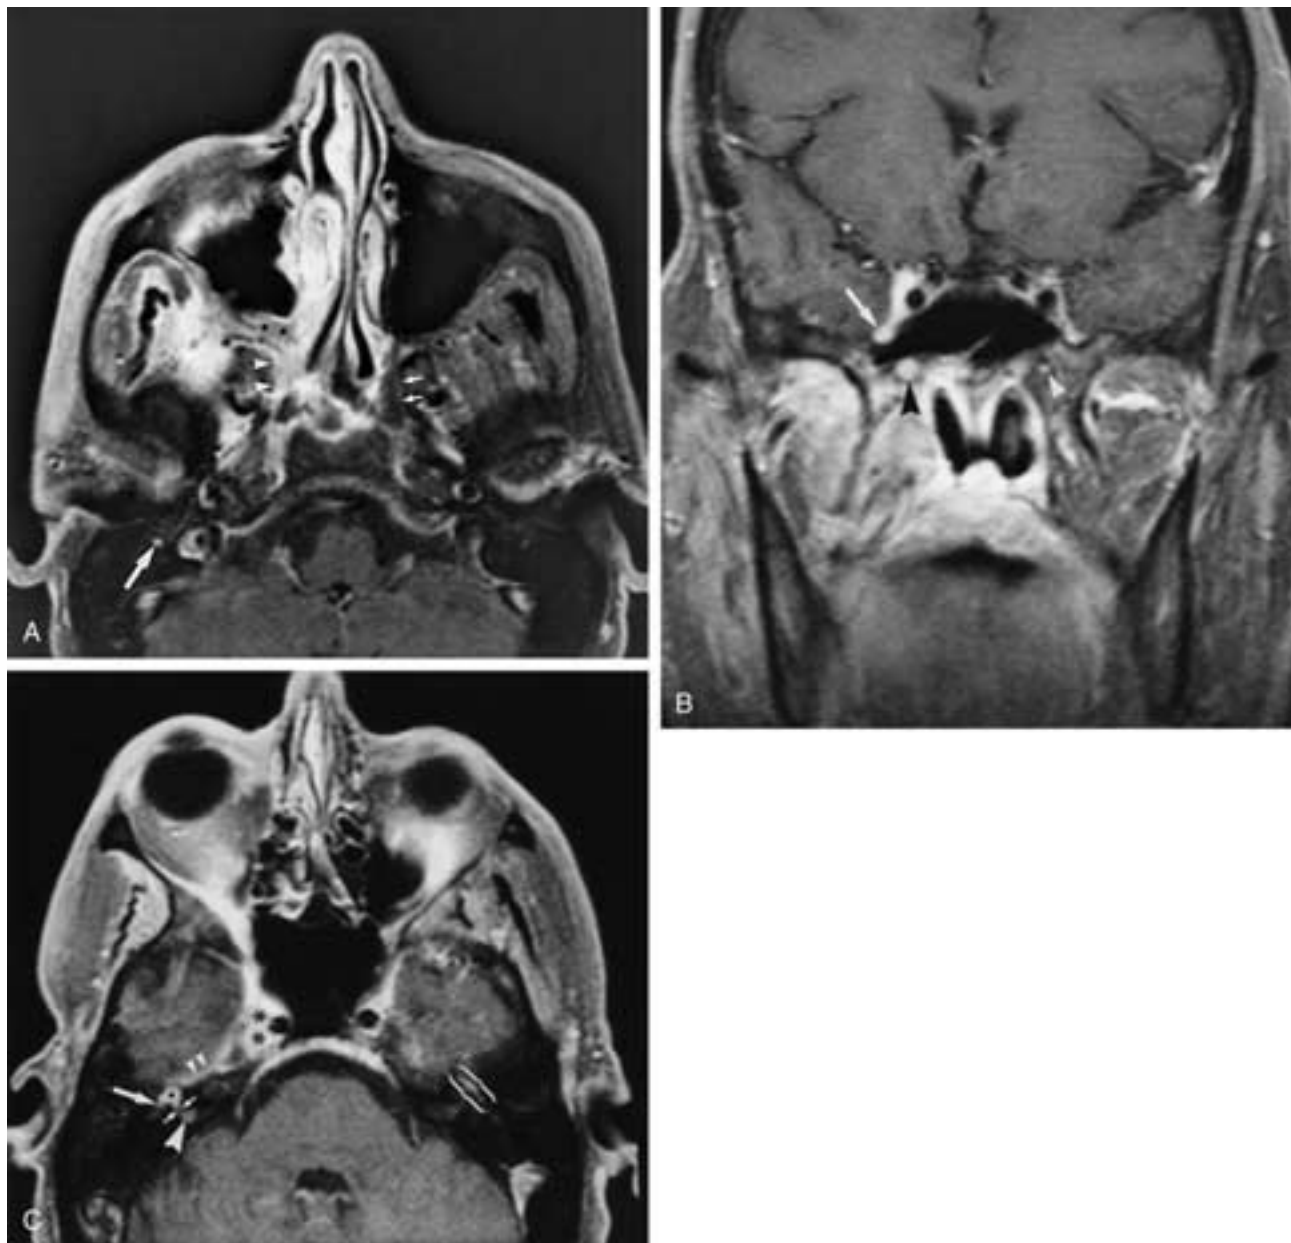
Palatal adenoid cystic carcinoma with extensive PNS. This patient was initially believed to have trigeminal neuralgia because of facial pain. A cavernous sinus/Meckel's cave mass was subsequently discovered on MR imaging. The palatal primary was not discovered until much later, and the patient ultimately developed a right-sided facial palsy. A, Axial contrast-enhanced, fat-suppressed T1-weighted MR image shows tumor enhancement in the right PPF (*black dots*). There is enlargement and excessive enhancement in the right vidian canal (*arrowheads*) indicating PNS along the vidian nerve. The normal left vidian canal is only faintly seen (*short arrows*). There is probably abnormal enhancement in the descending segment of the right facial nerve (*long arrow*). B, Coronal contrast-enhanced, fat-suppressed MR image shows enlargement and excessive enhancement representing PNS in both the right foramen rotundum (*arrow*) and the right vidian canal (*black arrowhead*). The cavernous sinus looks abnormal as well. The left vidian canal shows normal enhancement (*white arrowhead*). C, Axial contrast-enhanced, fat-suppressed MR image shows tumor involvement of the right cavernous sinus and the anterior aspect of Meckel's cave (*asterisks*). The greater superficial petrosal nerve courses directly beneath this area, as shown in [Figure 13-18](#). There is abnormal enhancement indicating PNS along the greater superficial petrosal nerve (*small arrowheads*). The geniculate ganglion enhances brightly and is grossly enlarged (*black dot*). There is abnormal enhancement representing continued tumor spread to involve the labyrinthine (*small arrows*), intracanalicular (*large arrowhead*), and proximal tympanic (*large arrow*) segments of the right facial nerve. On the left side, the geniculate ganglion is of normal size (and enhances normally), and only the proximal GSPN and the proximal tympanic segment of the facial nerve enhance (*brackets*). (From Ginsberg LE, DeMonte F, Gillenwater AM. Greater superficial petrosal nerve: anatomy and MR findings in perineural tumor spread. *AJNR* 1996;17:389–393.)
